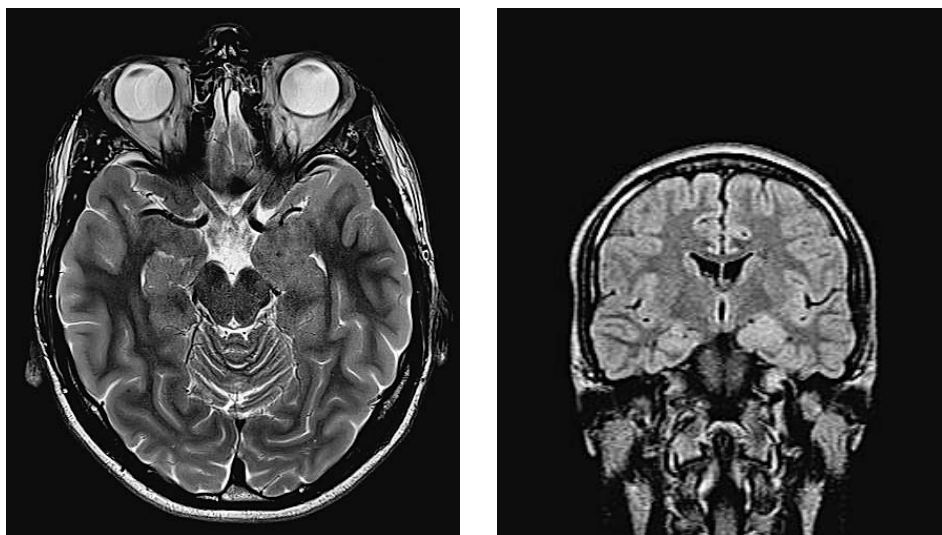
Preoperative magnetic resonance imaging (MRI) of the brain (T2 axial weighted image): pathologic lesion in the region of the left-sided uncus and amygdala. Note the increased volume of the uncus and amygdala and absence of perilesional edema (A). Note the blurring and hyperintense signal of the left amygdala on coronal FLAIR axial MRI reformations (B).
